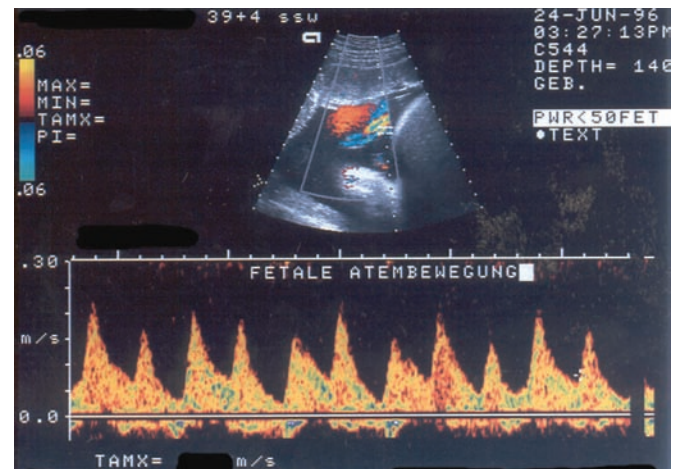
Pitfalls in umbilical artery Doppler velocimetry (fetal breathing).
